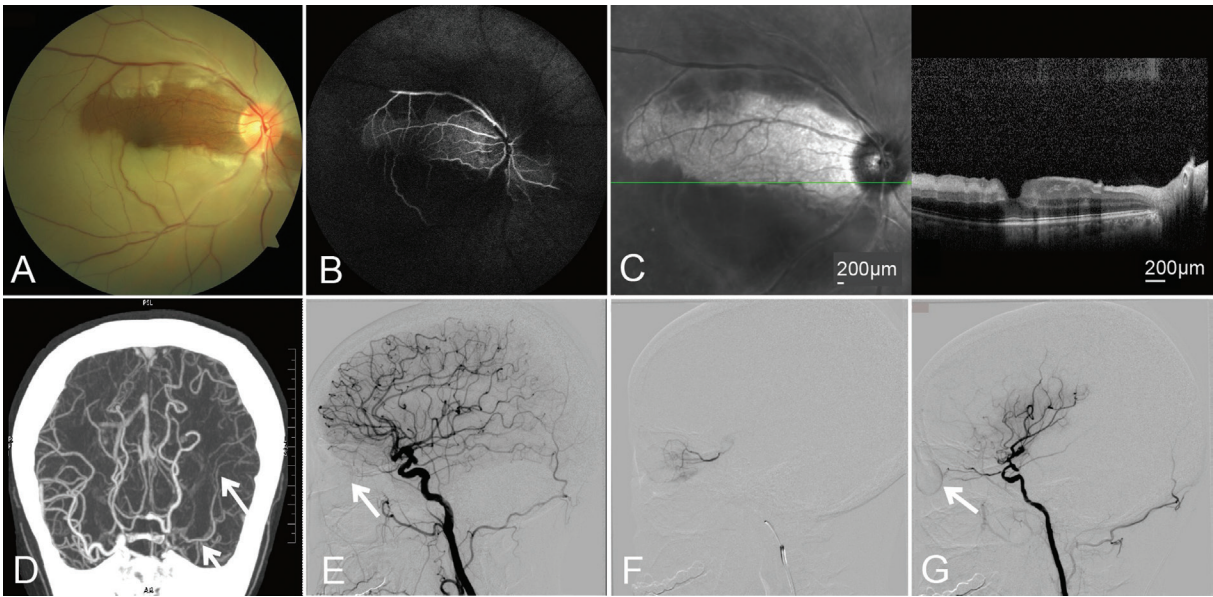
Case 2 imaging findings A: Fundus photograph of the right eye at presentation; B: FFA image captured at 20s; C: OCT image of the right eye at presentation; D: CTA image showing left MMD; E: Cerebral angiography before thrombolytic injection; F: Cerebral angiography during the thrombolytic injection; G: Cerebral angiography after the thrombolytic injection. FFA: Fundus fluorescein angiography; OCT: Optical coherence tomography; CTA: Computed tomography angiography; MMD: Moyamoya disease.
